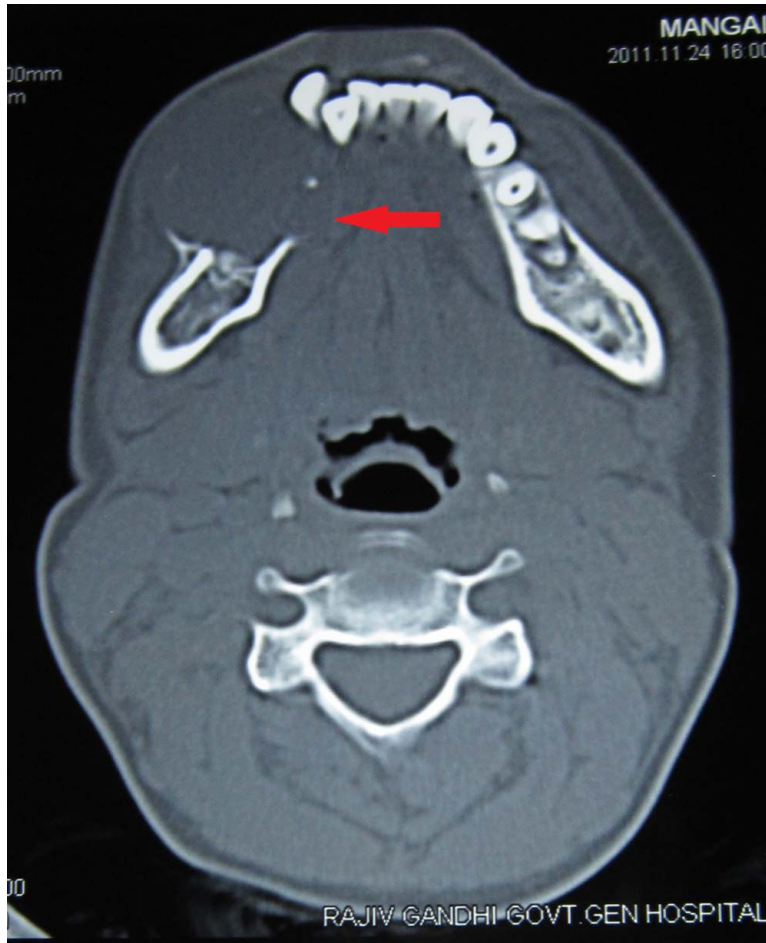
Axial CT scan section showing homogenous, hypodense lesion
